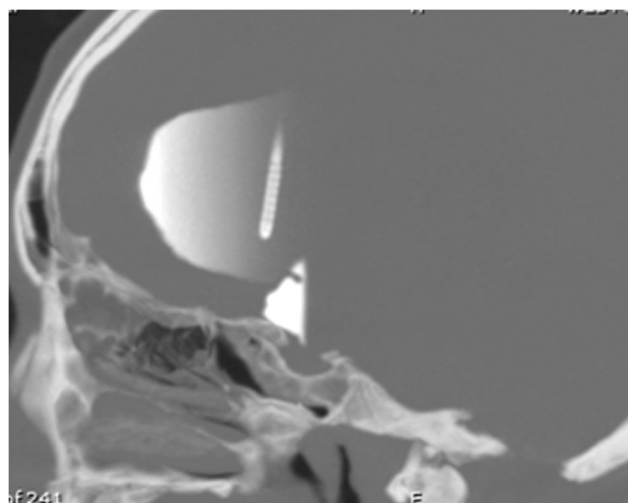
Failed ETV. Sagittal computed tomography scan of the brain acquired after injection of 10 cc of Omnipaque 180 into the OR. No evidence of contrast opacification is seen beyond the third ventricle or in the basal cisterns
